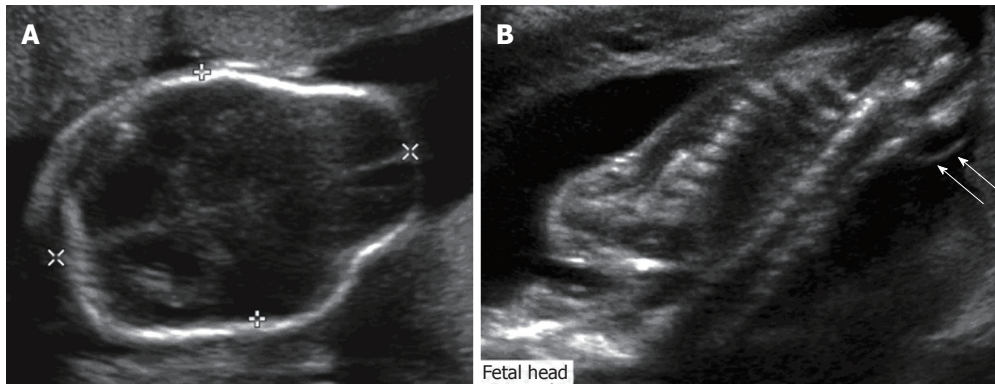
Fetal ultrasound. Grayscale ultrasound images of the fetal head (A) and spine (B) demonstrate ventriculomegaly as well as a lemon-shaped configuration of the fetal head due to bifrontal concavity, typical of Chiari II malformation. There is an associated myelomeningocele (arrows).
